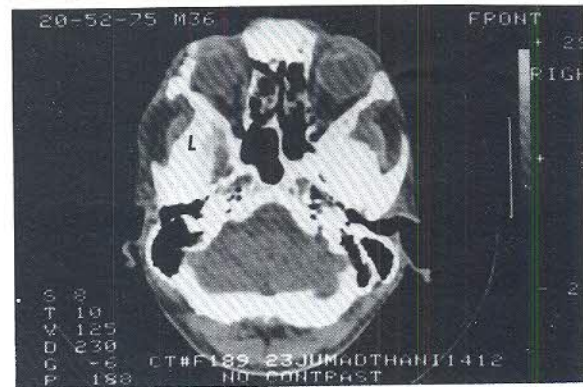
Case 3. CT scan (without contrast) taken 1 year after surgery shows no evidence of recurrence of the mucocoele.
